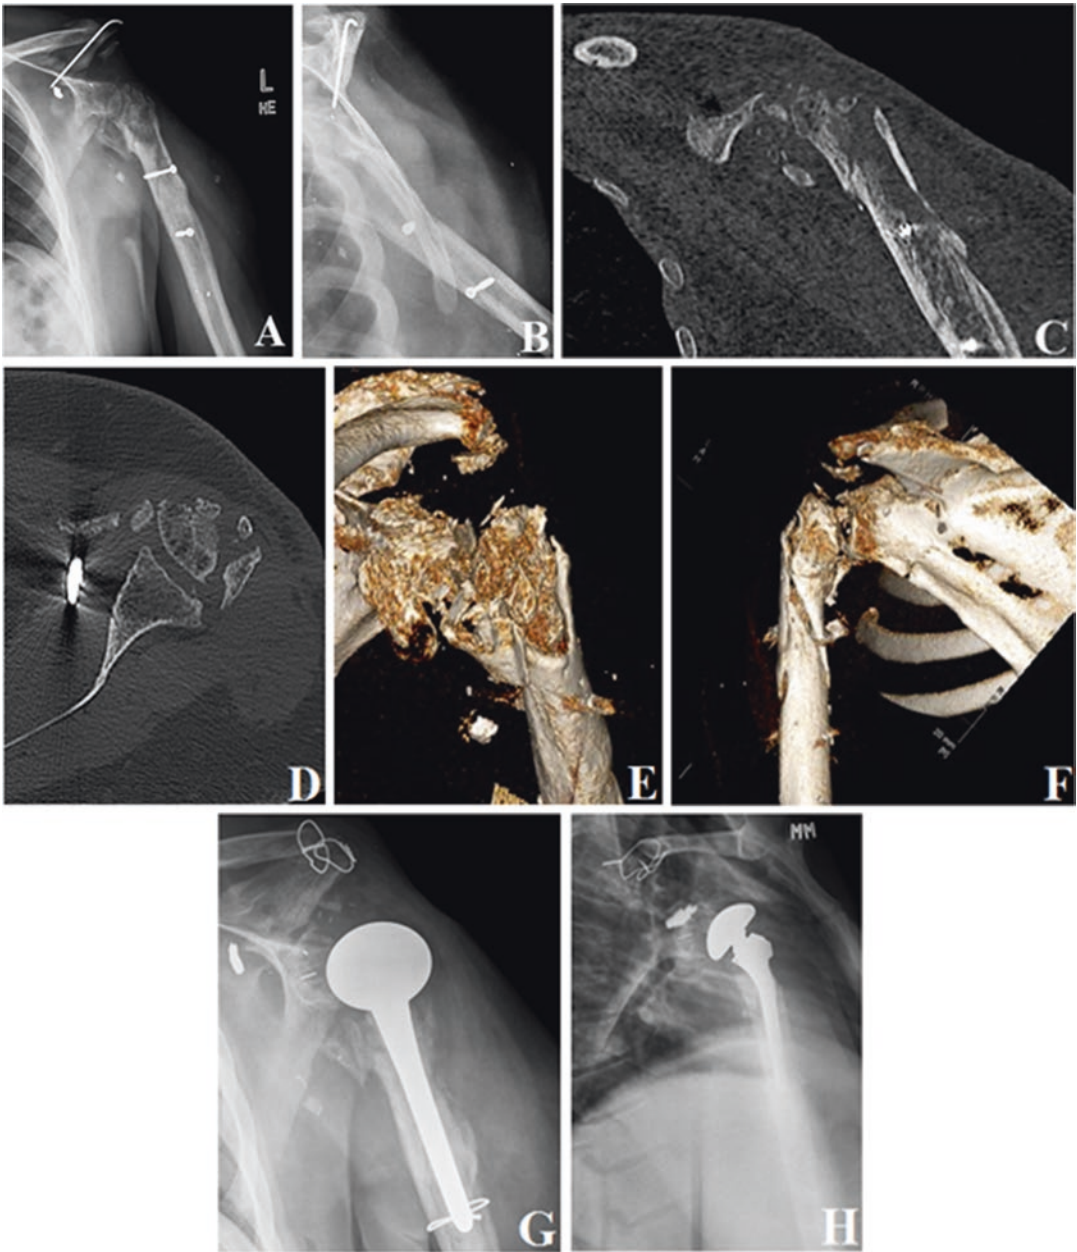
A 26-year-old man with left shoulder blast injury. (a, b) Loss of humeral head and acromion, fracture of glenoid fossa. Nonfunctional shoulder. (c, d) Coronal and axial cuts of CT scan showing the humeral head comminution, glenoid fracture, and loss of bone. (e, f) 3D reconstruction
